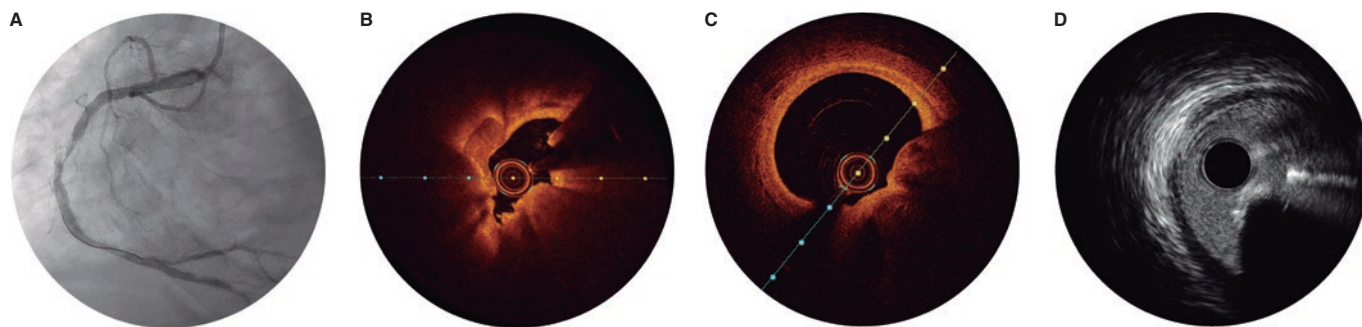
Calcified nodule appearance on angiography (A), optical coherence tomography (eruptive [B] and non-eruptive [C]) and intravascular ultrasound (D).
